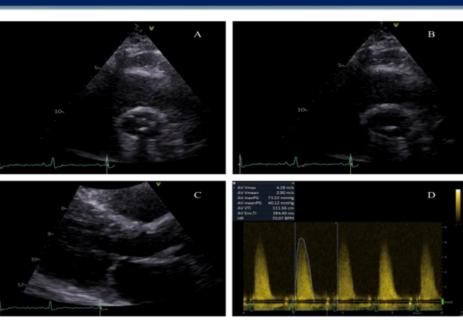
Echocardiogram: Short axis view with closed AV (A) and open AV (B), showing good excursion. Parasternal long axis view with open AV (C). Doppler AV velocity and PG measurements (D).
